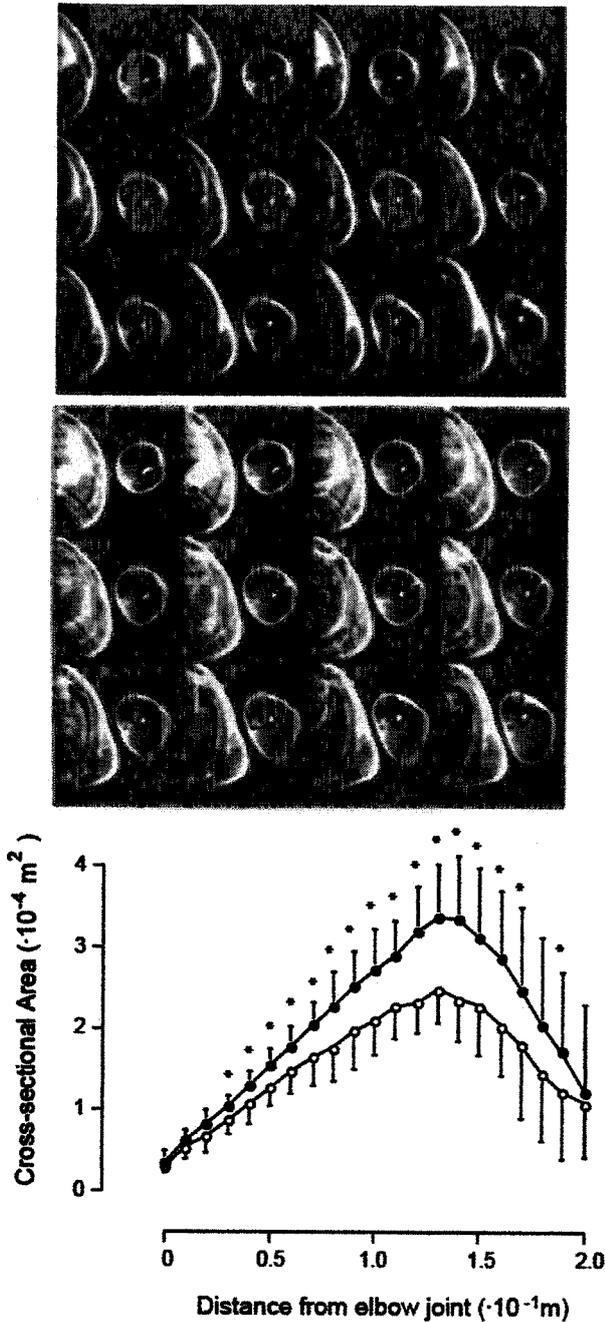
Series cross-sectional MRI images of the upper arm (from top left to bottom right; distal to proximal) before (upper panel) and after (lower panel) strength training of elbow flexor muscle for 16 weeks. The series anatomical cross-sectional areas before (○) and after (●) training are also shown (bottom trace) (Kawakami et al., 1995). In each image, triceps brachii muscles are seen in the lower half of the upper arm.
